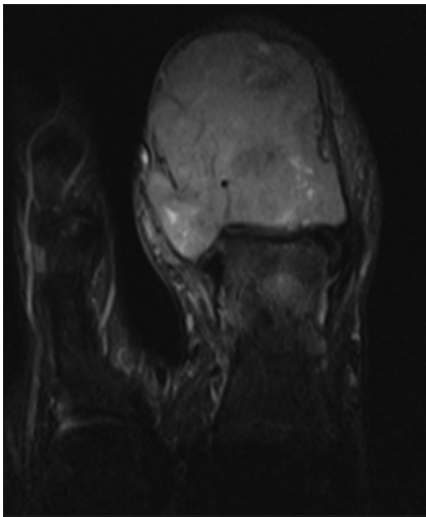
Post contrast T1-Weighted MRI revealed mild patchy enhancement of the lesion
